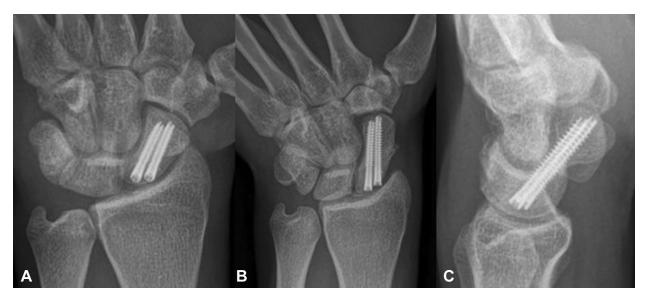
Six-month follow-up A posteroanterior, B navicular, and C lateral radiographs show healed fracture without complication.
